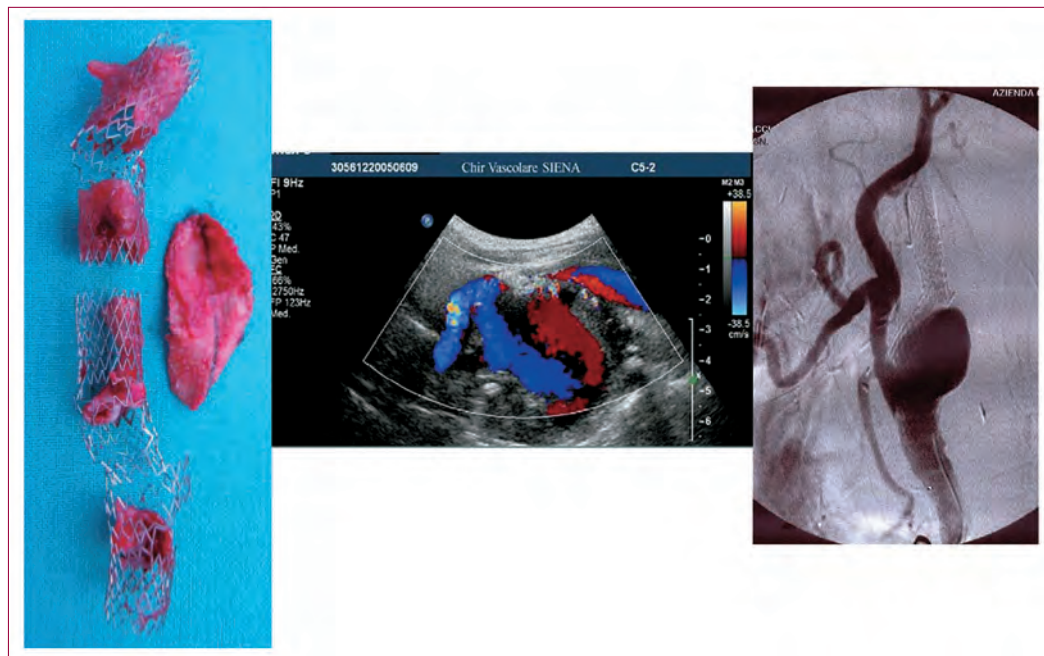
Intraoperative, eco-color-Doppler and angiographic findings of carotid false aneurysm following stent fracture after CAS.
